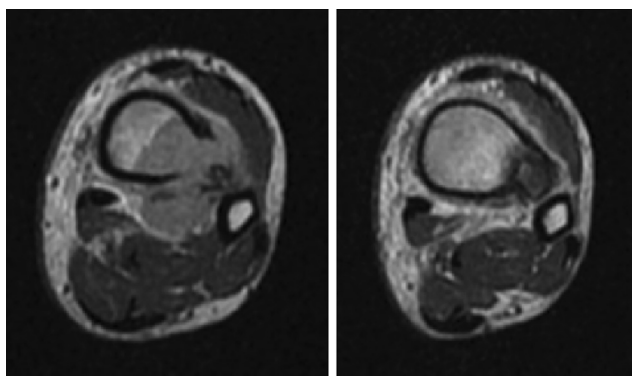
Pre-chemotherapy MRI: see on the left the destructive lesion of the tibia and on the right the NOF.
